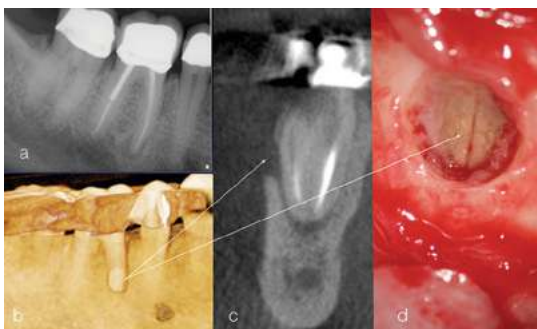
Example of the sensitivity of CBCT in detecting vertical root fractures. Periapical radiograph of tooth #30 (A). 3-D reconstruction demonstrating the mid-root buccal defect (B) (arrow). Line corresponds to mid-root buccal plate fenestration. Coronal view demonstrating the mid-root buccal bone loss (C) (arrow). Surgical degranulation of the defect confirming the vertical root fracture in the mesial root (D) (arrow).
